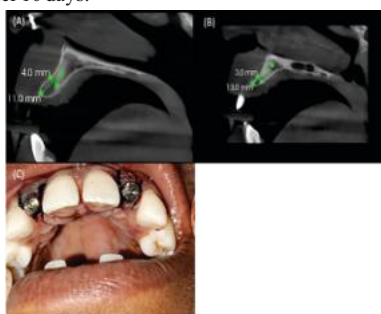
(A) Patient's initial situation. CBCT images of regions 12 and (B) 22 showing agenesis of maxillary lateral incisors and reduced bone of facial width, (C) final position of implants showing comfort caps screwed and sutured.
